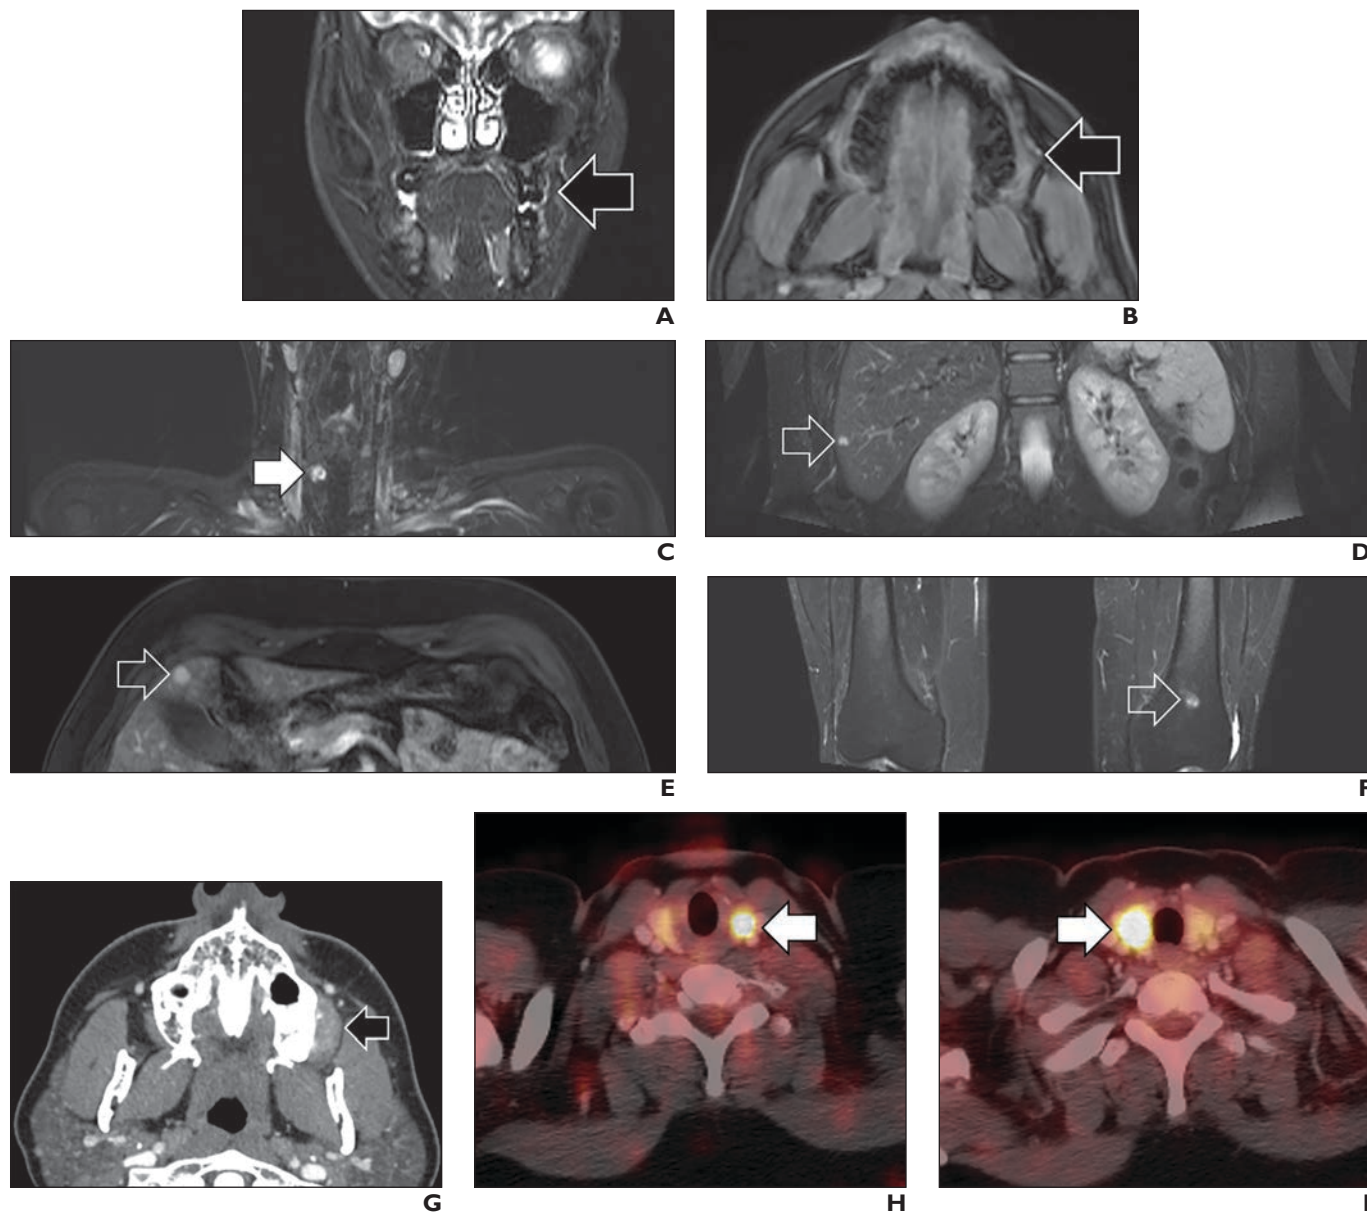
35-year-old patient with Li-Fraumeni syndrome, no personal cancer history, and family history of pancreatic cancer and breast cancer. A and B, Coronal STIR image (A) and axial postcontrast T1-weighted image with fat saturation (FS) (B) from baseline whole-body MRI (WB-MRI) show normal left maxilla (arrow). C, Coronal STIR image from baseline WB-MRI shows thyroid nodules (arrow). Additional thyroid nodule was detected on baseline WB-MRI (not shown). Thyroid nodules were considered likely benign due to small size and multiplicity. D, Coronal STIR image from baseline WB-MRI shows hepatic lesion (arrow), which had been characterized as cyst on previous abdominal MRI (not shown) performed due to family history of pancreatic cancer. E, Axial postcontrast T1-weighted image with FS from baseline WB-MRI shows enhancing hepatic focus (arrow) that was characterized as perfusion-related phenomenon on previous abdominal MRI (not shown). F, Coronal STIR image from baseline WB-MRI shows lesion (arrow) in distal left femur that was characterized as enchondroma on conventional radiography (not shown). Patient's insurance carrier declined coverage of 1-year follow-up WB-MRI examination. Patient developed palpable facial mass approximately 2 years after baseline WB-MRI. G, Axial contrast-enhanced CT image obtained 2 years after baseline WB-MRI to assess facial mass shows soft-tissue mass (arrow) arising from left maxilla. Biopsy of mass showed osteosarcoma. H and I, Serial axial fused FDG PET/CT images obtained for staging of osteosarcoma 2 years after baseline WB-MRI show FDG-avid lesions in thyroid gland (arrows). Biopsy revealed bilateral papillary thyroid carcinomas. Patient underwent treatment, including cytotoxic chemotherapy, for these malignancies. Patient developed therapy-related myelodysplastic syndrome (MDS) 3 years later and died 1 year after diagnosis of MDS. This case shows challenges of incidental findings, interval cancers, and reimbursement when performing WB-MRI.
